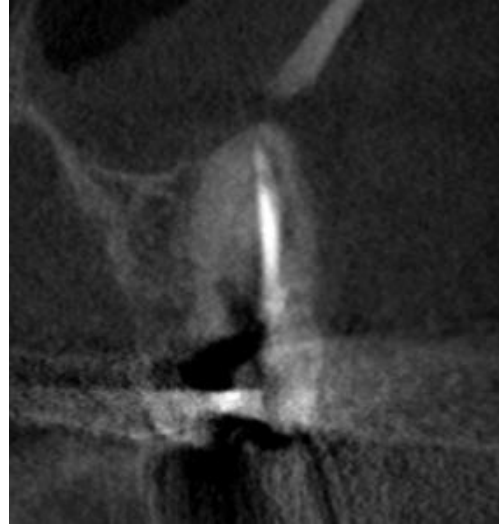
CBCT Coronal View of Mesiobuccal Root of #14
